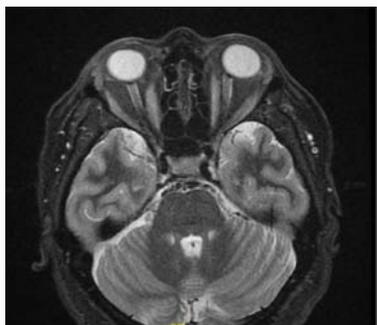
Orbital MRI showing hyperintensity in the inferior rectus and contrast enhancement along with bilateral exophthalmos.
